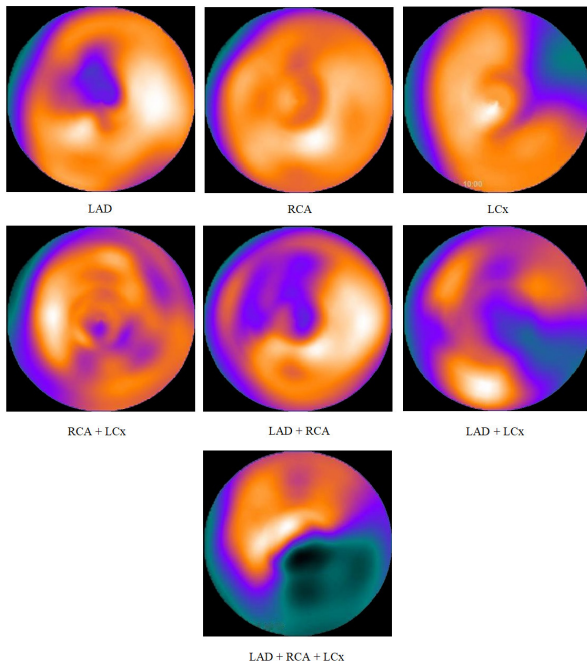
Examples of SPECT images in our datasets.
